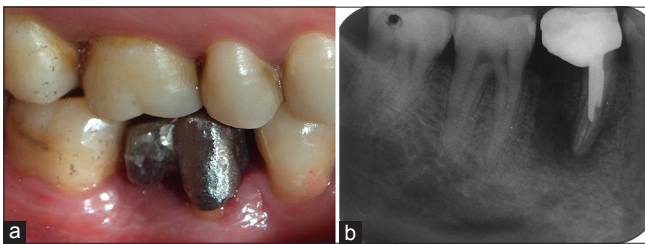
Cast framework try-in through (a) clinical examination, and (b) periapical radiograph
